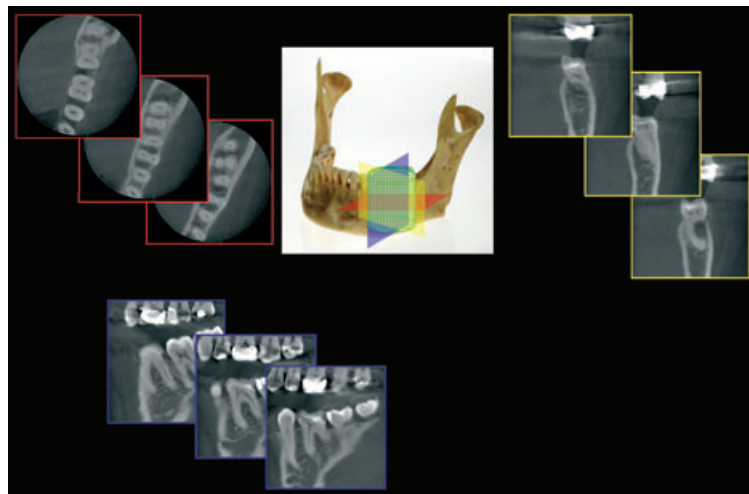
Typically cross-sectional images in three orthogonal views are generated from the cone beam computed tomography scan. The clinician selects the position and thickness of the slice selected from within cylindrical or spherical volume of data. The three views can be assessed simultaneously, traversing through one plane simultaneously alters the other two planes.
